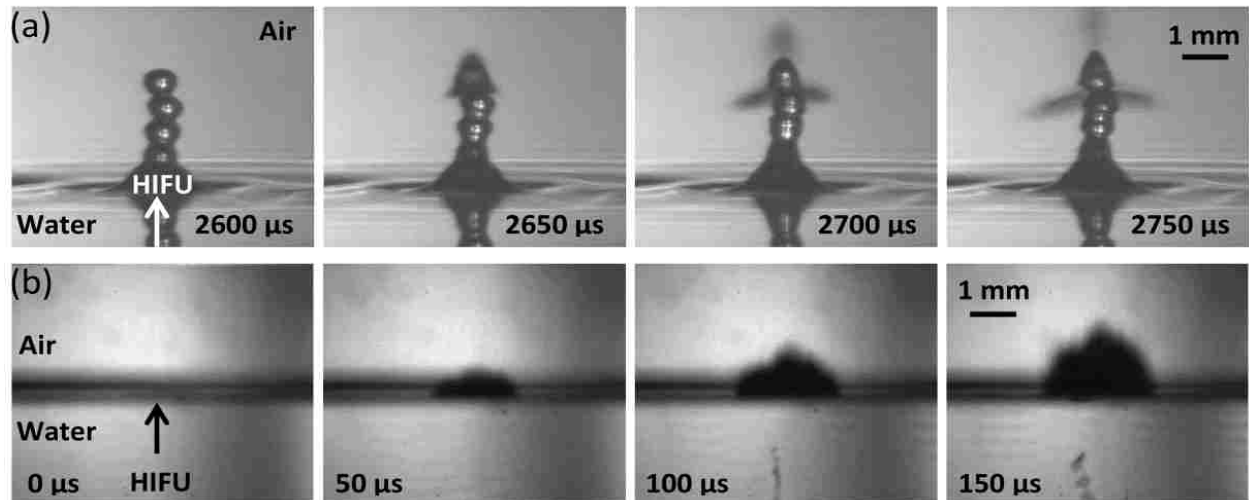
Air-water interface filmed with (a) the objective in air such that the reflections we see in the bottom of the frames are due to an optical reflection of the same jet and (b) the objective positioned so that half the objective is facing air and the other half facing water to observe effects in water and air simultaneously. (a) Shows a sequence of images taken at very low intensities (180 W/cm^2) with the camera positioned at a slightly downward angle to catch the surface of the water. Atomization does not occur until the drop chain emerges. At some point, the top drop becomes unstable and atomization jets are released. (b) A sequence of images showing the air to water interface at high acoustic intensities of $24,000 \text{ W/cm}^2$. Cavitation occurs before atomization or jetting and is faintly visible just to the right of the HIFU arrowhead in the first frame, which is taken $20 \mu\text{s}$ after the acoustic wave arrives at the water surface. As the ultrasonic pulse continues, the cavitation bubbles just below the water surface are joined by a cavitation bubble cloud further below the surface, possibly due to the standing wave pattern that develops upon the reflection of the acoustic wave. Total ultrasound exposure times were 10-ms.
